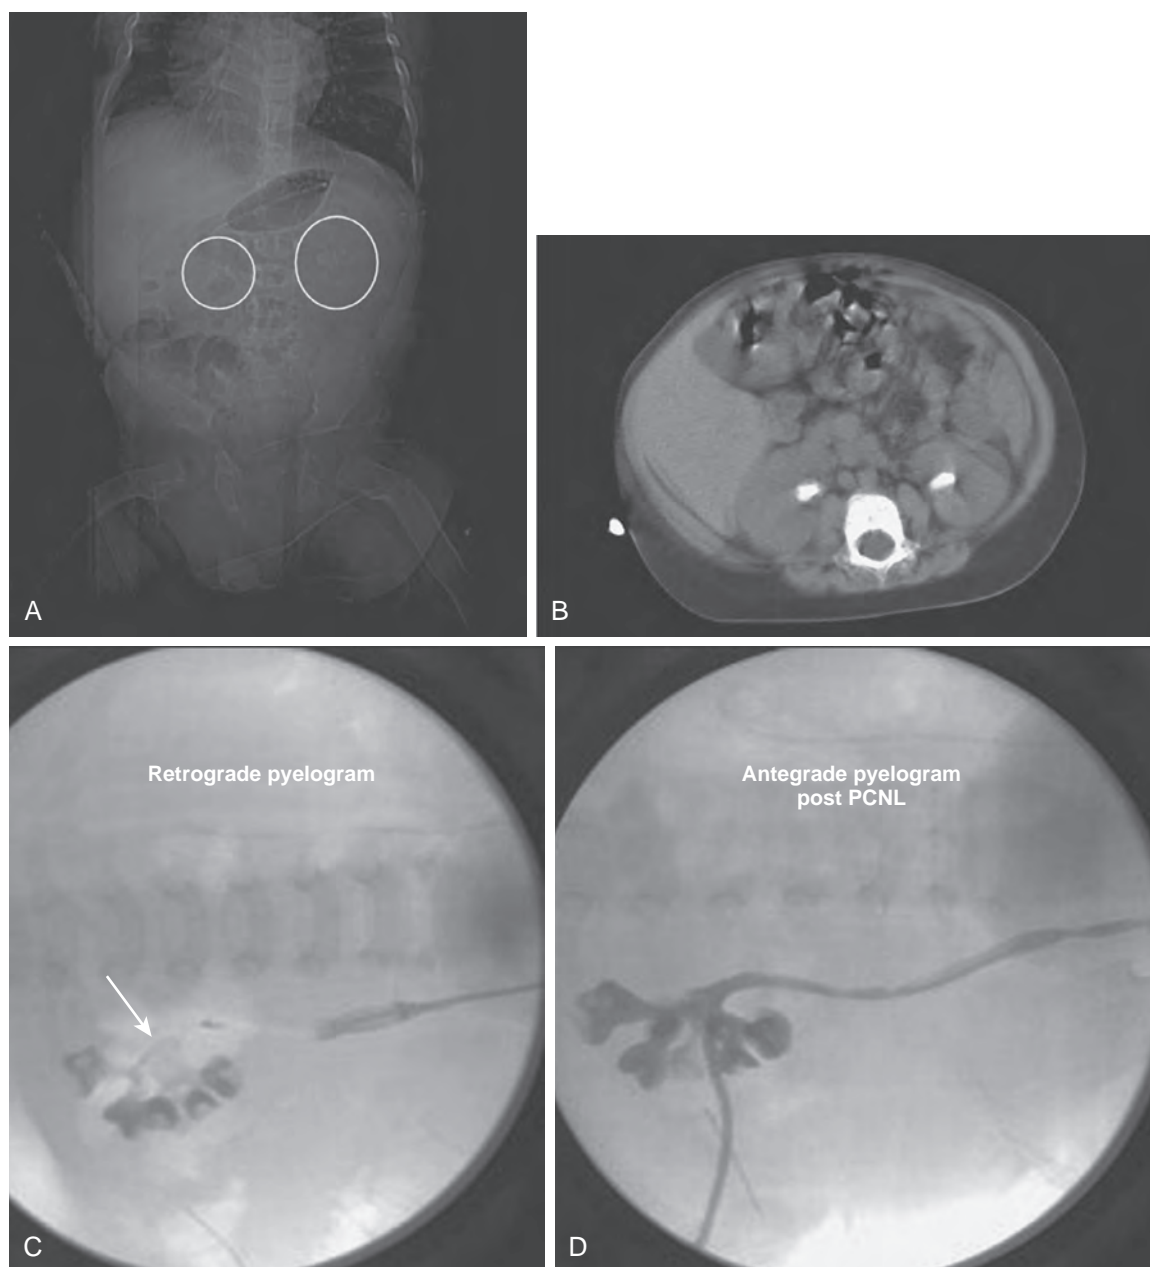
A 22-month-old boy with intractable diarrhea of infancy from tufting enteropathy who awaited a small bowel transplant. Risks for nephrolithiasis included dependency on total parenteral nutrition, osteomalacia, chronic dehydration, hypocitruria, and hyperoxaluria. A, Kidney-ureter-bladder film demonstrated mildly radiopaque stones. B, Subsequent computed tomography scan confirmed bilateral staghorn calculi. C, Prone view of left retrograde pyelogram of child in A, demonstrating staghorn calculi as a filling defect (*arrow*). A mini-perc technique was used to address the stones. D, Prone view of the antegrade nephrostogram through a 6-Fr nephrostomy tube demonstrating “stone-free” status. PCNL, percutaneous nephrolithotomy.
